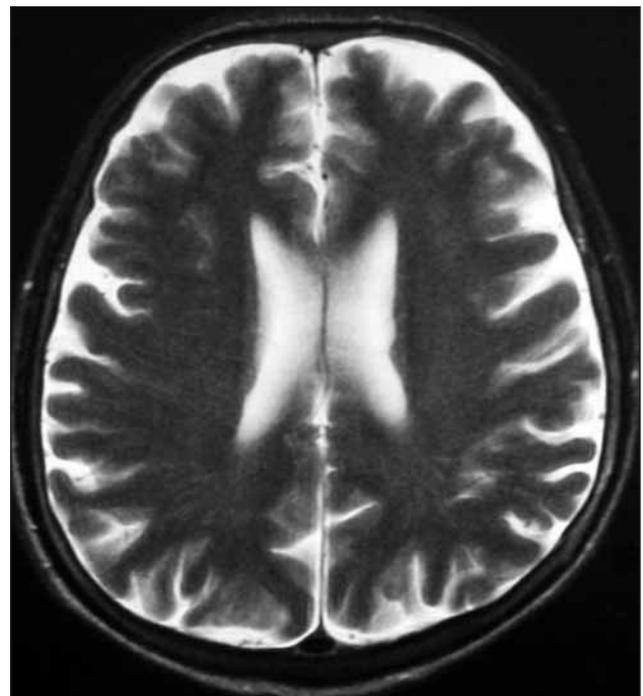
Preoperative axial MRI of brain showing no apparent pathology.
